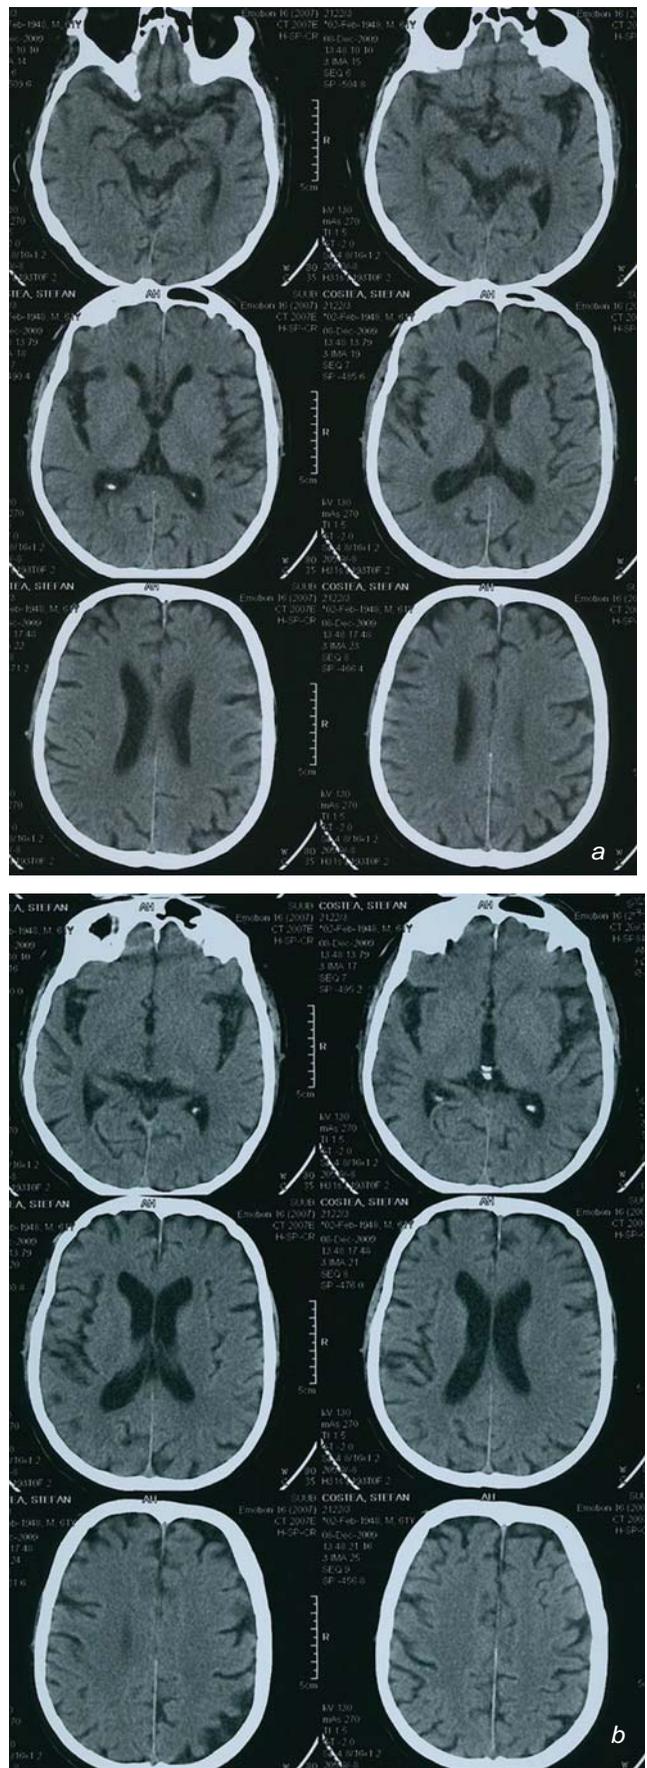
a) Cerebral CT scan showing no acute ischemic signs and moderate brain atrophy; b) Cerebral CT scan showing no acute ischemic signs and moderate brain atrophy
